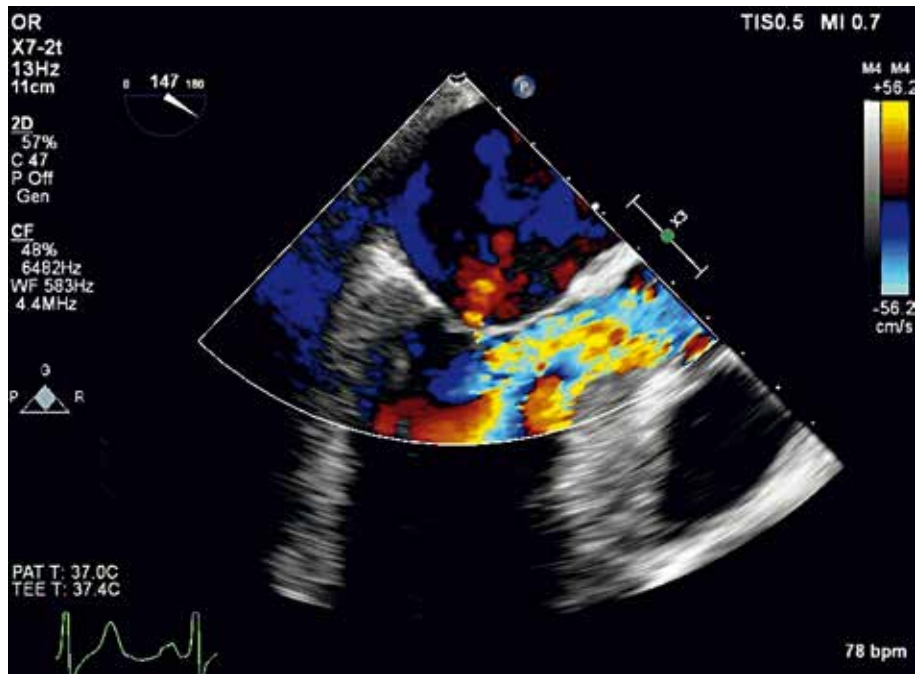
Picture obtained from transesophageal echocardiographic examination demonstrating LVOT after haemodynamic collapse
